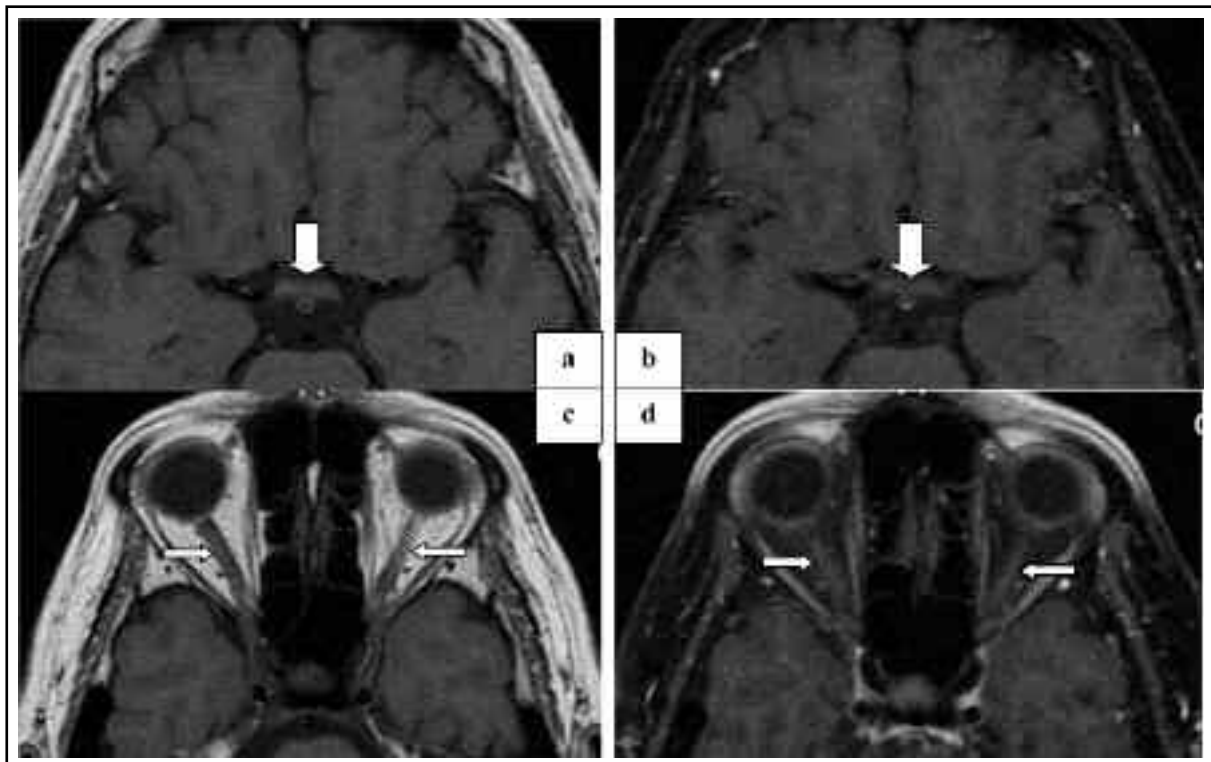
(2a and 2c - T1WI: 2b and 2d - T1WI with gadolinium): MRI of the orbit at presentation shows enhancement of the optic chiasma (wide arrow) and bilateral optic nerve enhancement (narrow arrow).
